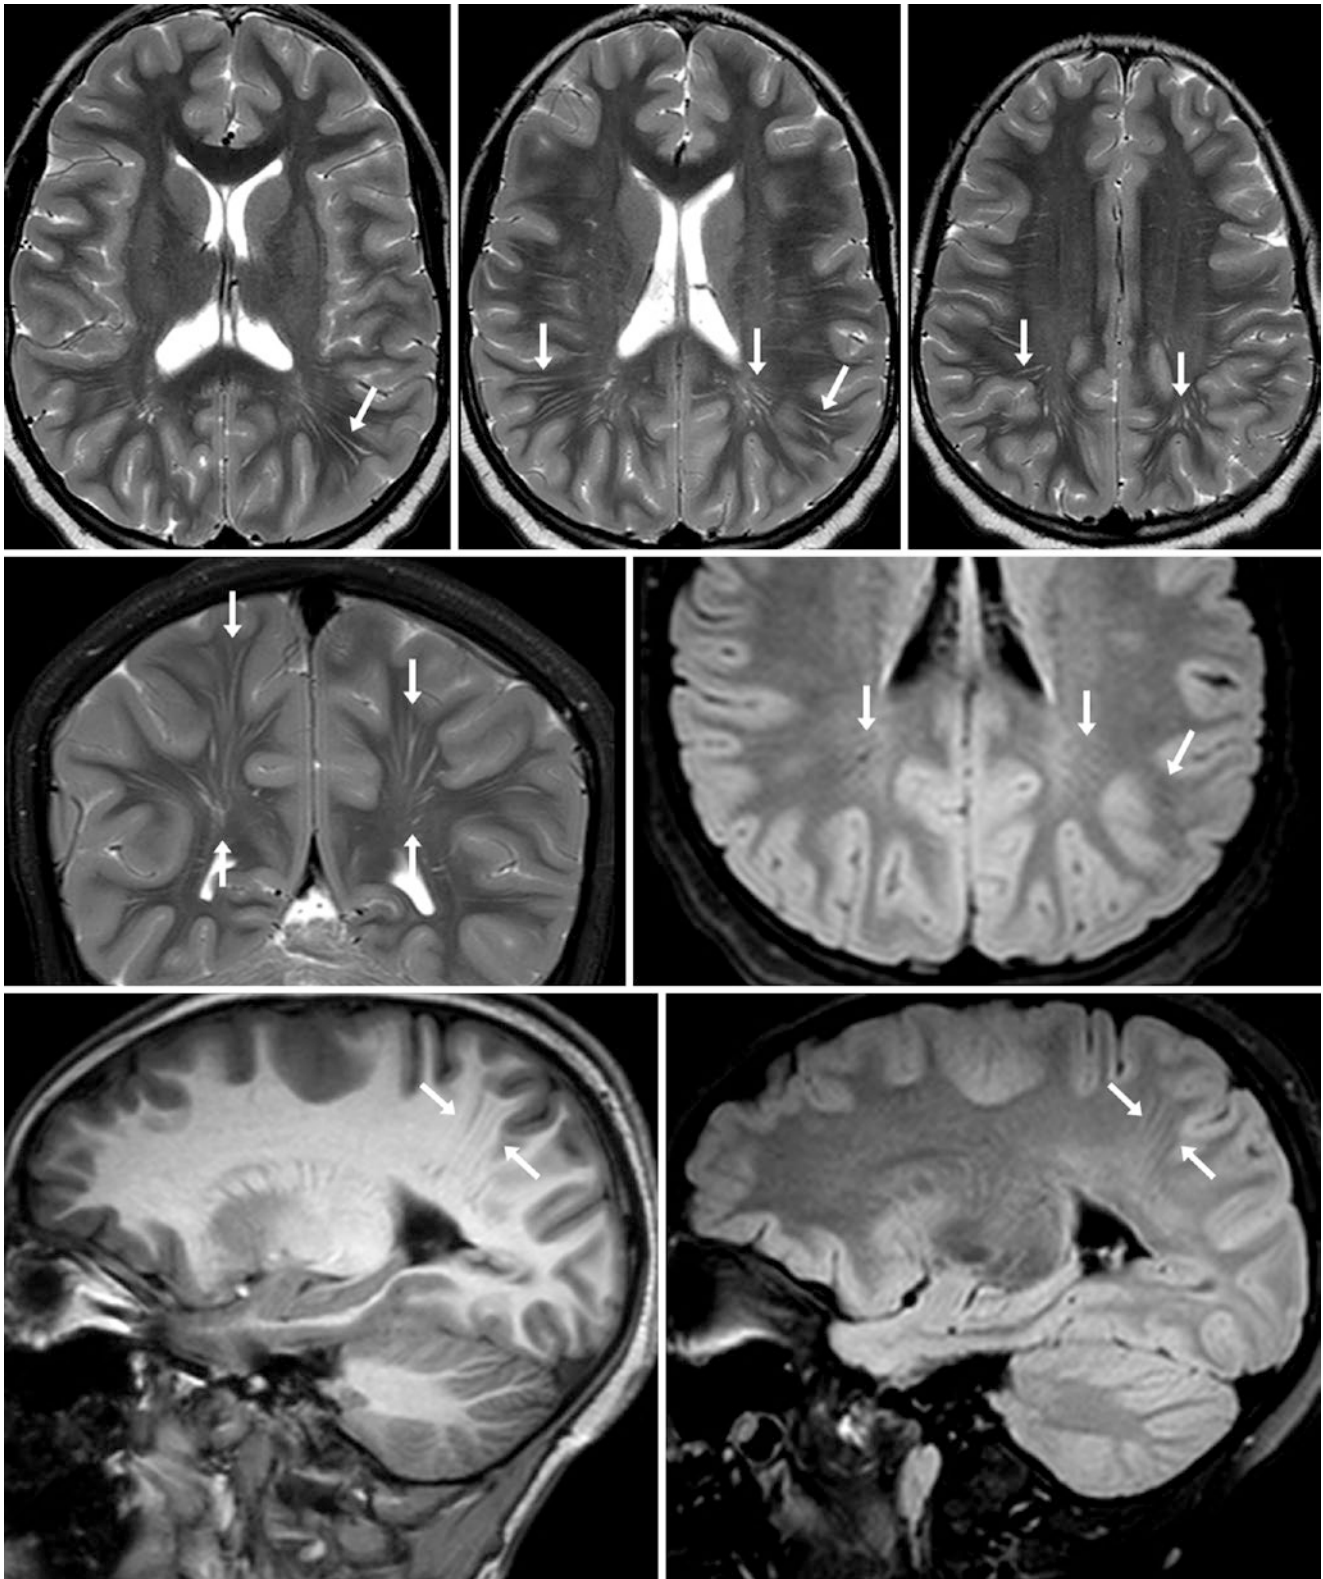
The patient is an 8-year-old normal boy with a history of seizures. *Top row:* on a 3T MRI, there are bilateral dilated PVSs within the deep parietal white matter (*arrows*) on T2WI. Note their linear appearance that radiates from the lateral ventricles and the lack of overlying cortical atrophy or gliosis. The MRI was otherwise interpreted as
